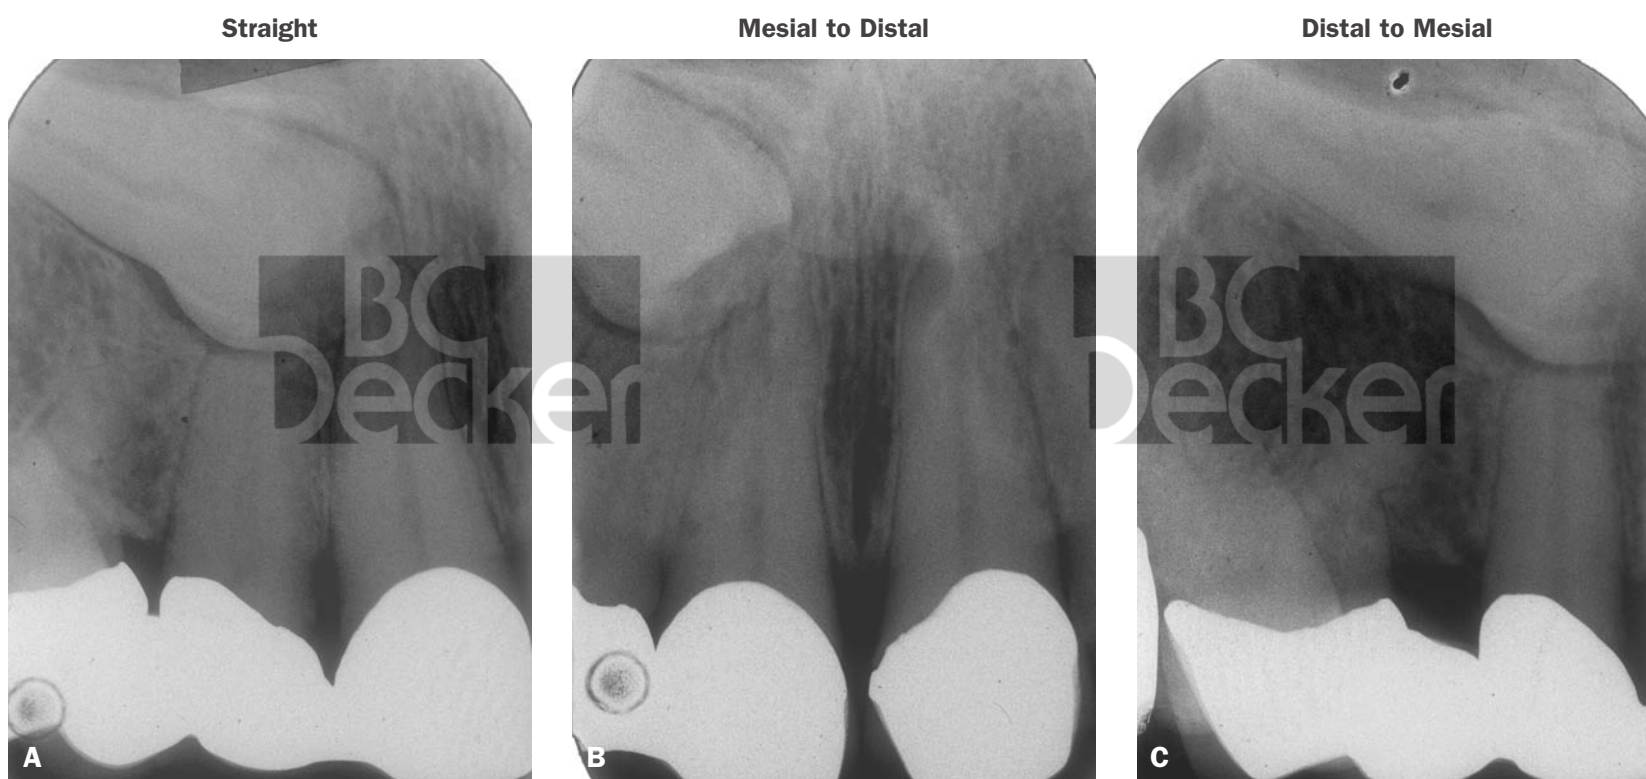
Radiographic examination for localization of an impacted tooth. A, Radiograph taken straight on. B, Radiograph taken mesial to distal. C, Radiograph taken distal to mesial. Note movement of the tooth with the change in angulation.
